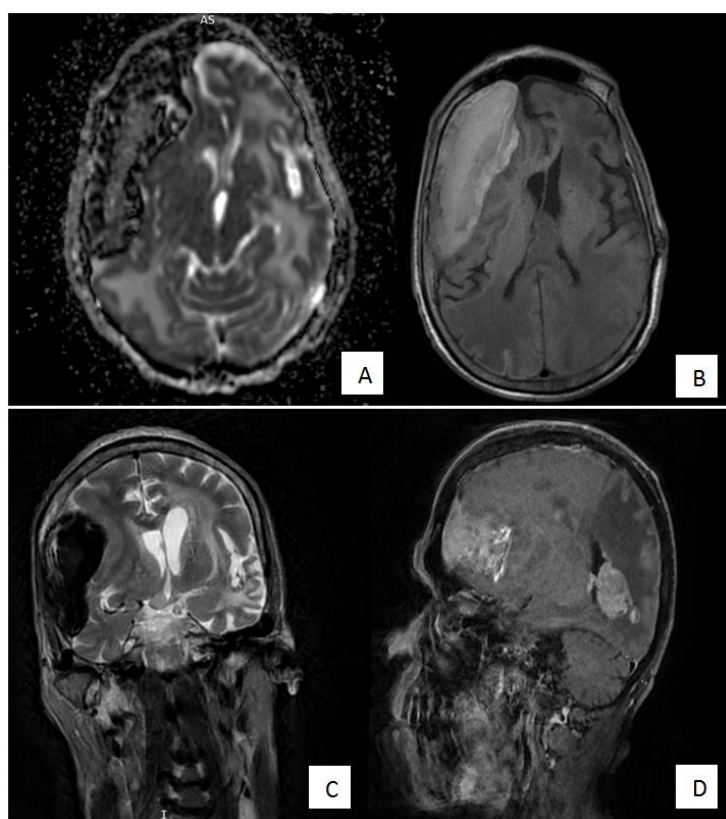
Cranial MRI images of the right fronto-parietotemporal chronic subdural hematoma (A) ADC image showing hypointense region with necrotic debris within the capsule of the hematoma. (B) Axial T1 Image showing hyperintensity of the lesion with midline shift and right ventricular effacement. (C) Coronal T2 image showing a hypo intensity of the lesion (D) Sagittal contrast image showing contrast enhancement.
